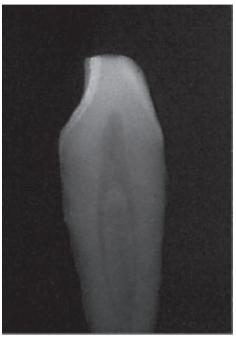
Lateral Periapical Radiograph showing a labial and a lingual root canal
